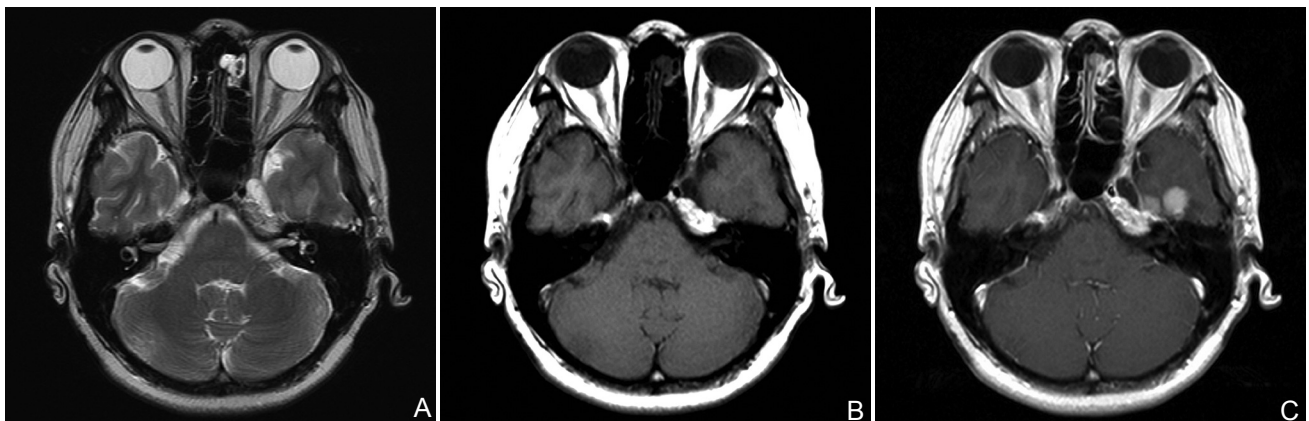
Magnetic resonance images in a patient with the left middle cranial fossa meningeiomas. (A) Axial unenhanced T₂w image, (B) Axial unenhanced T₁w image; the tumors are difficult to detect in unenhanced images (A and B). (C) Gadobutrol-enhanced T₁w image; two tumors are clearly demonstrated.
